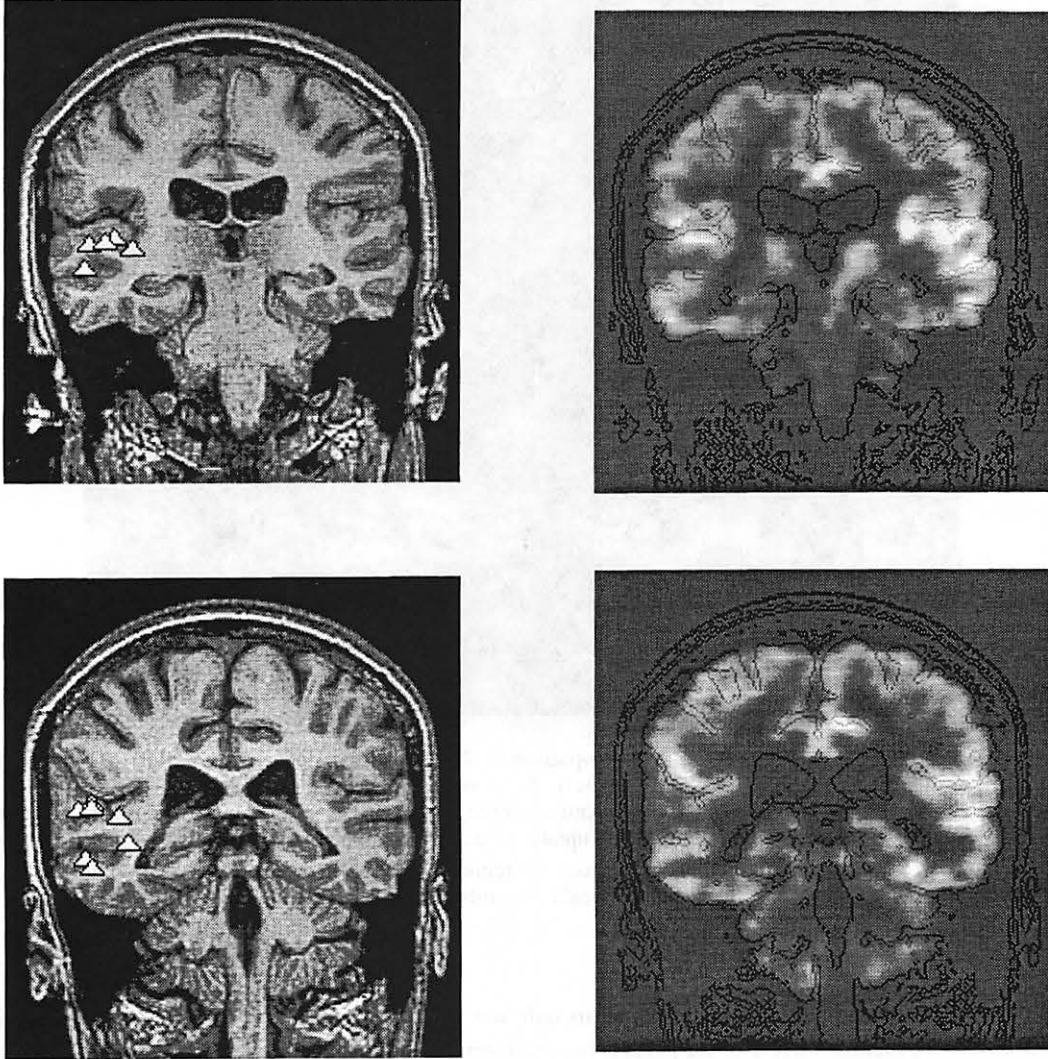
MRI-PET-MEG co-registration to detect a focal electrophysiologic and metabolic interictal disturbance. Left--MEG spike dipole source localization (white triangles) overlaid on selected co-registered coronal MRI slices from the temporal lobes--dipole sources correspond to an active disturbance of epileptiform activity recorded bipolarly over the right temporal lobe with scalp-sphenoidal EEG (sharp waves maximum at T4); the MRI is normal. Right--corresponding FDG-PET slices with overlaid contours from MRI anatomy--focal hypometabolism is present in the right superior temporal gyrus, remarkably colocalized with MEG spike sources. Pathologic examination cortical resection confined to the superior temporal gyrus and superior bank of the posterior middle temporal gyrus revealed hamartomatous dysplasia. Co-registration was performed with AIR[®].
